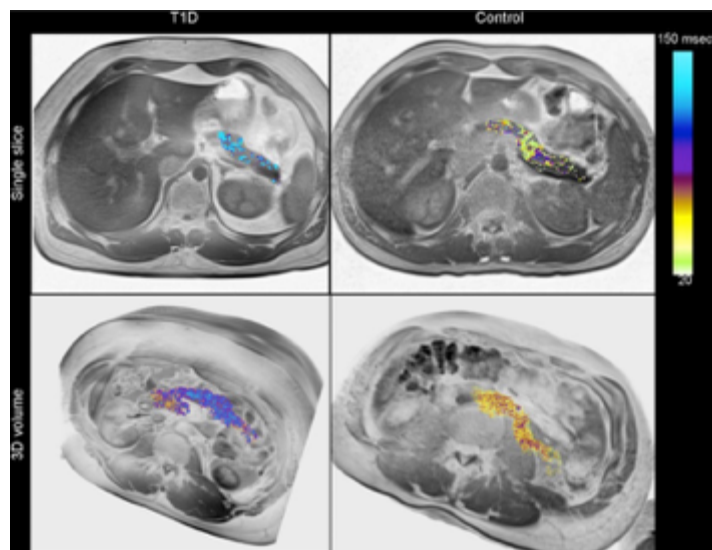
MR imaging of insulinitis.
